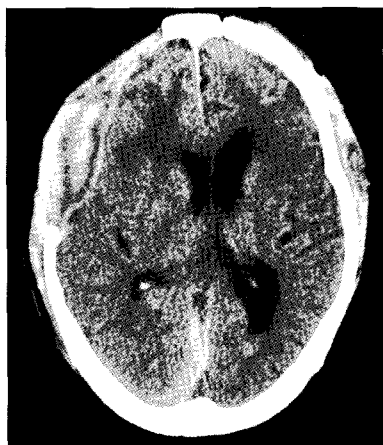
Postoperative axial CT scan 2 weeks later showing the resolved hematoma in the right frontotemporoparietal region and left frontal lobe. Note the restoration of the shifted midline.
